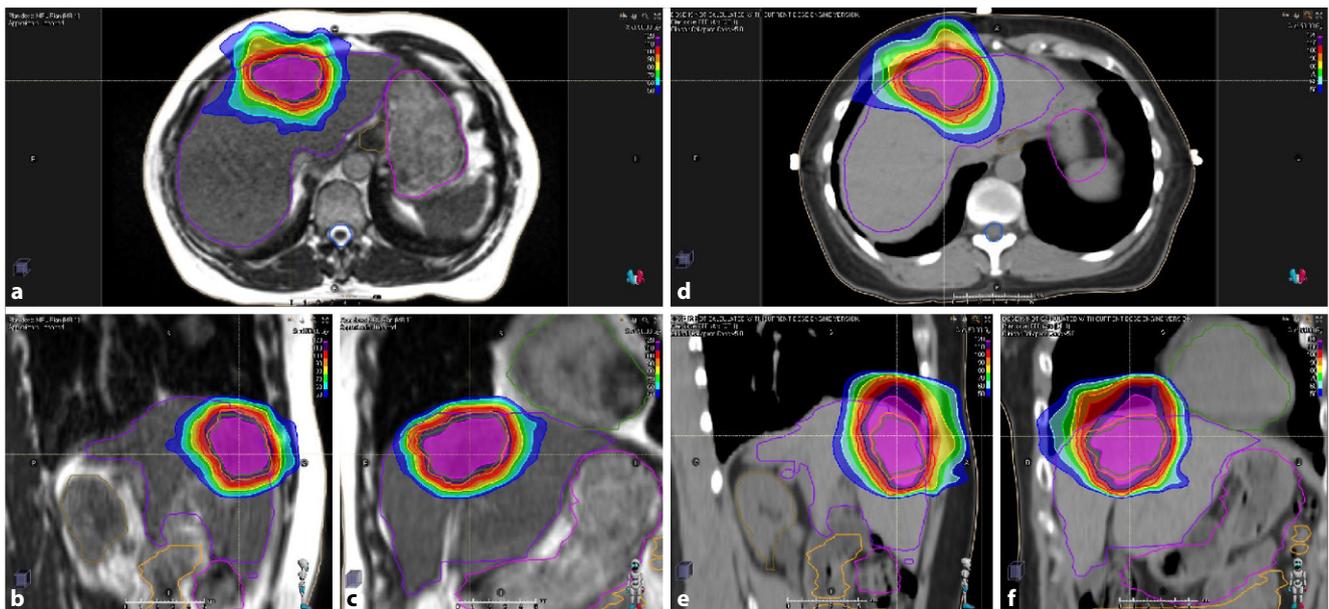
▲ Treatment plan for patient 2 (liver metastasis) as applied at the magnetic resonance(MR)-Linac using gated treatment in breath-hold (a–c: axial, sagittal and coronal images). Retrospectively generated computed tomography-based plan with internal target volume (ITV) showing a much larger treatment volume compared with the MR-Linac plan (d–f: axial, sagittal and coronal images)
